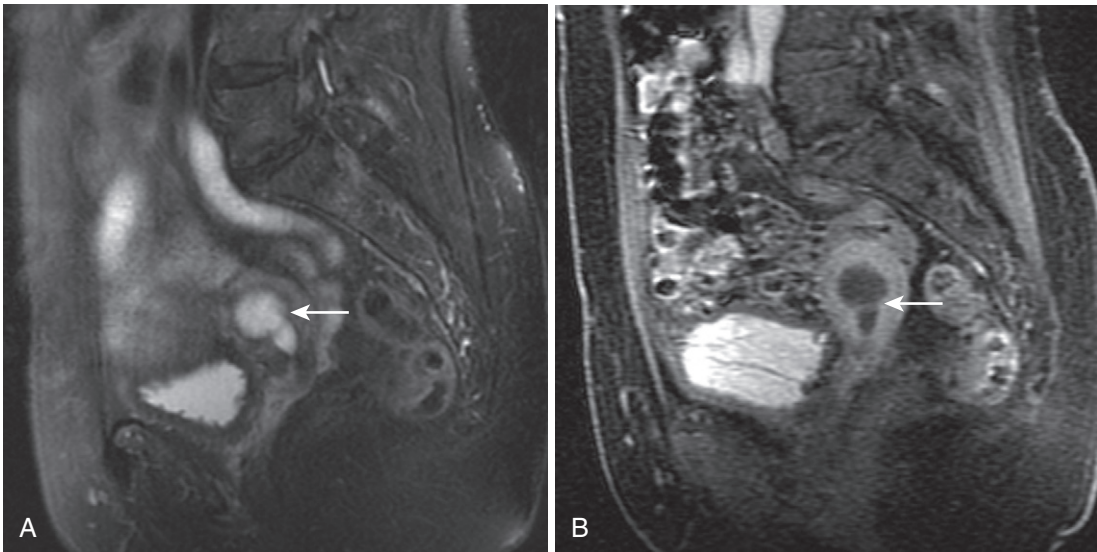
Intrauterine adhesions. Sagittal T2-weighted fat-saturated (A) and T1-weighted fat-saturated postgadolinium gradient echo (B) images show fluid distention of the endometrial canal proximal to an adhesion at the level of the internal cervical os (arrow).
